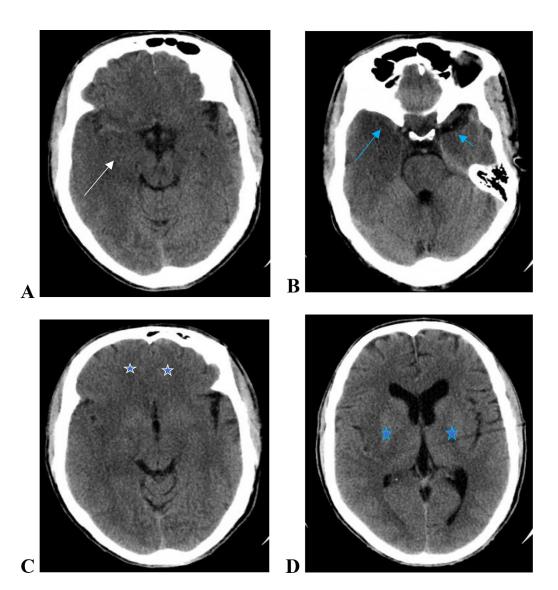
Non-contrast axial CT scan of the brain shows the following findings: medial and anterior portions of the right temporal lobe (indicated by the white arrow) exhibit low density and a loss of gray-white matter distinction(A). right insular cortex (indicated by the long blue arrow) and left mesial temporal lobe is (indicated by the short blue arrow). Both regions showed low density(B). both par-median lower frontal lobes are subtly characterized by a low density (indicated by the white stars) (C). bilateral basal ganglia, unaffected (indicated by the blue stars) (D).
